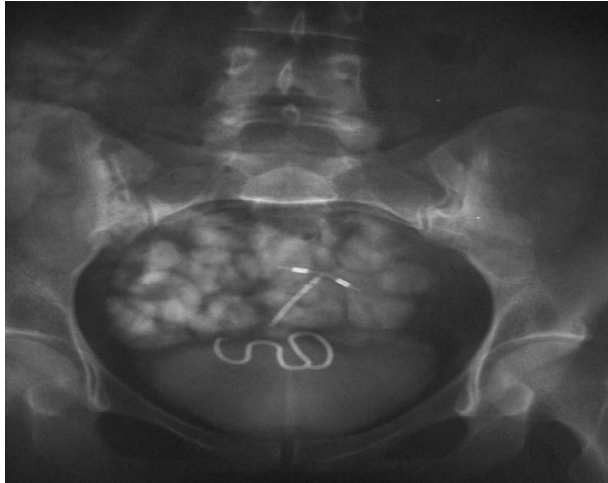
Two intrauterine devices seen on pelvic plain radiography.
